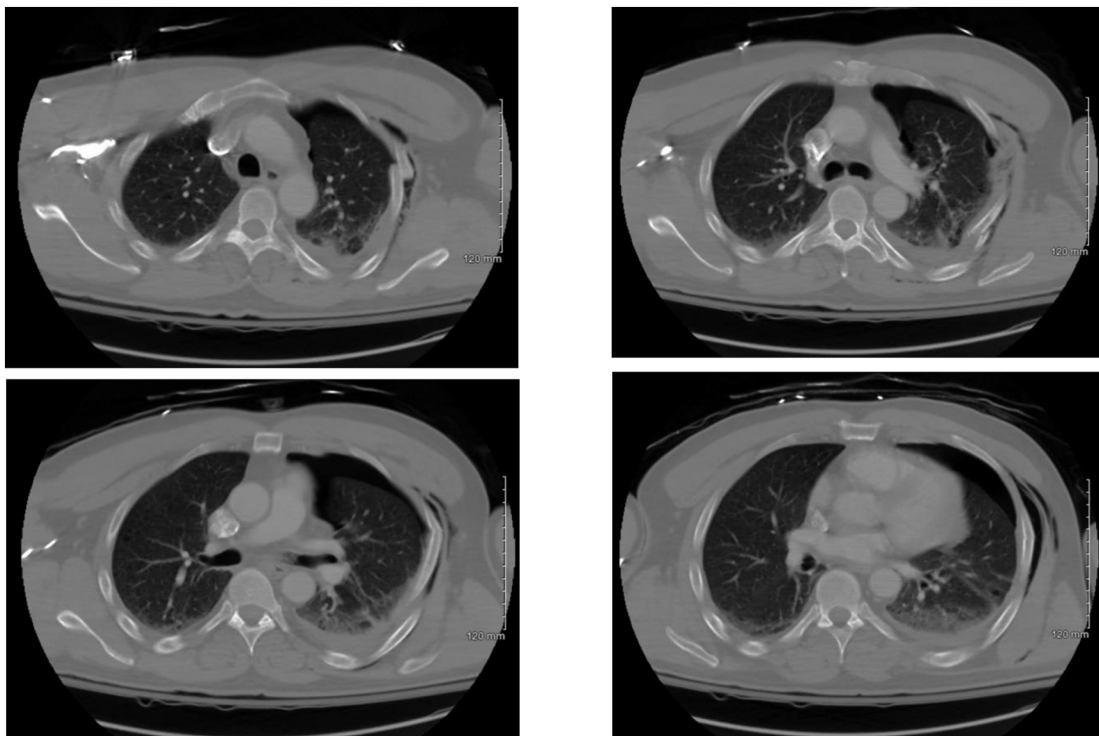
CT scan of rib fractures.
